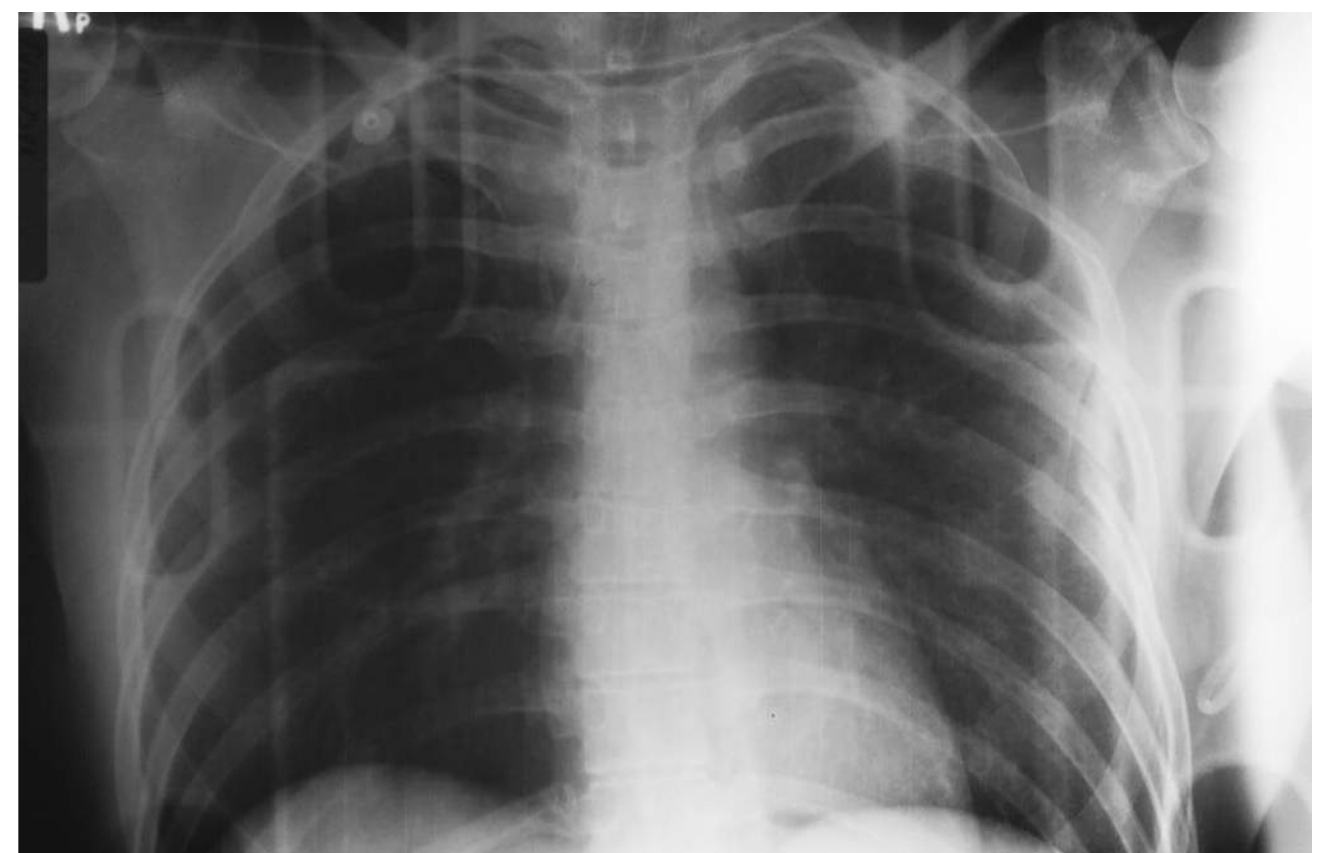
■ Flail Chest: Trauma Chest X-Ray. Fractures in two places of left ribs 3 and 4 result in a flail segment. Ribs 2 and 5 have single fractures. This is the chest x-ray of the patient in Fig. 7.5. (Photo contributor: Lawrence B. Stack, MD.)
